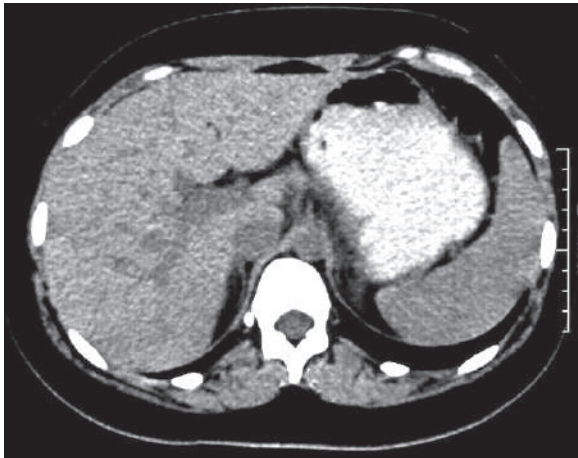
Axial nonenhanced CT of the abdomen shows high-density liver
